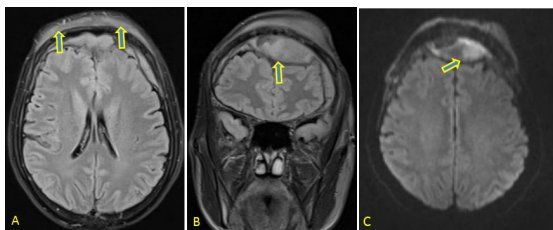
Pre-contrast MRI Brain.
